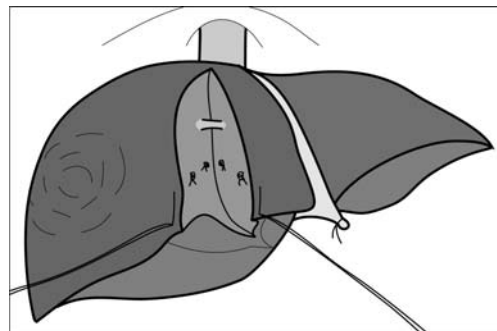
When dividing the liver parenchyma using an ultrasound dissector and bipolar diathermy, larger intrahepatic vessels are identified. These are dissected free using a right-angled forceps, divided between vascular clamps and secured using suture–ligature (3–0 absorbable suture) on a larger needle.
